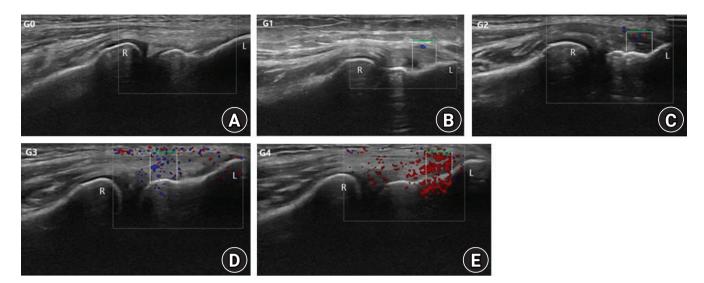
The grading of the color Doppler activity (CDA) on longitudinal ultrasonographic examinations of the common extensor tendon origin. The grading was performed in the region of interest (ROI) defined as a 0.5 cm longitudinal part of the tendon with maximum CDA. A horizontal green line measuring 0.5 cm marks the superficial border of the ROI, white dotted lines mark the proximal and distal borders, and the bone marks the deep border. Flow towards the transducer is depicted in red while flow away from the transducer is shown in blue. (A) G0, no activity. (B) G1, single vessel in the ROI. (C) G2, CDA in <25% of the ROI. (D) G3, CDA in 25%–50% of the ROI. (E) G4, CDA in >50% of the ROI. R: radial head, L: lateral epicondyle.
